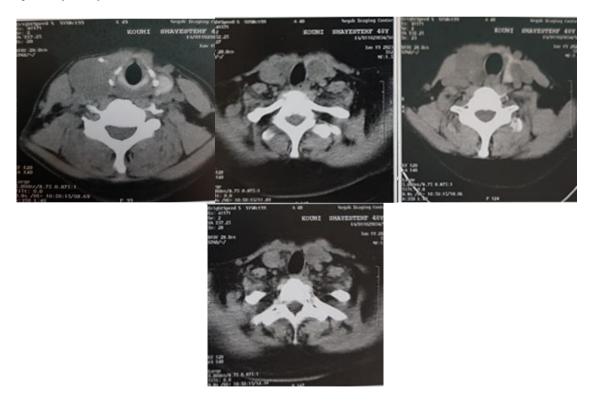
Computed tomography of the thyroid and neck showed thyroid nodules and cervical lymph nodes with homogenous enhancement pattern
